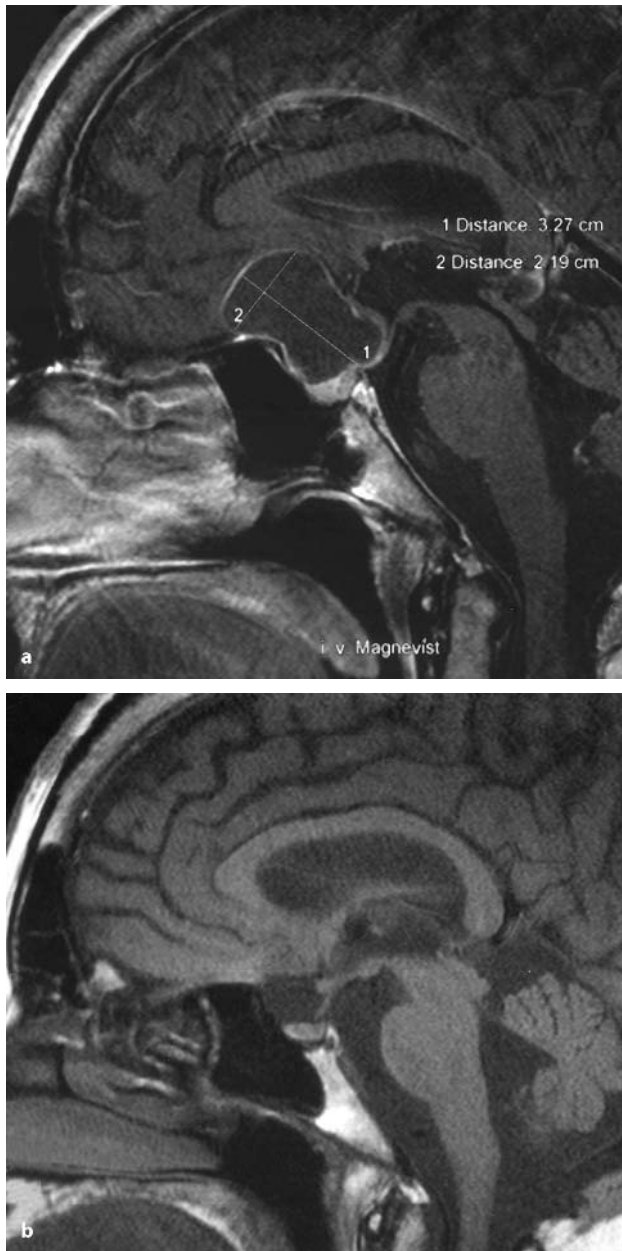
Pre- and postoperative sagittal MR images (a, b) of a cystic craniopharyngioma that was completely removed via a transnasal approach
